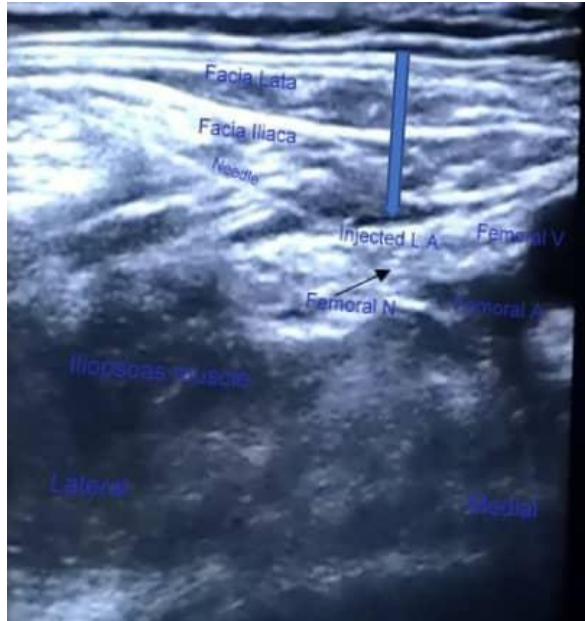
Ultrasound scan of fascia iliaca compartment block
